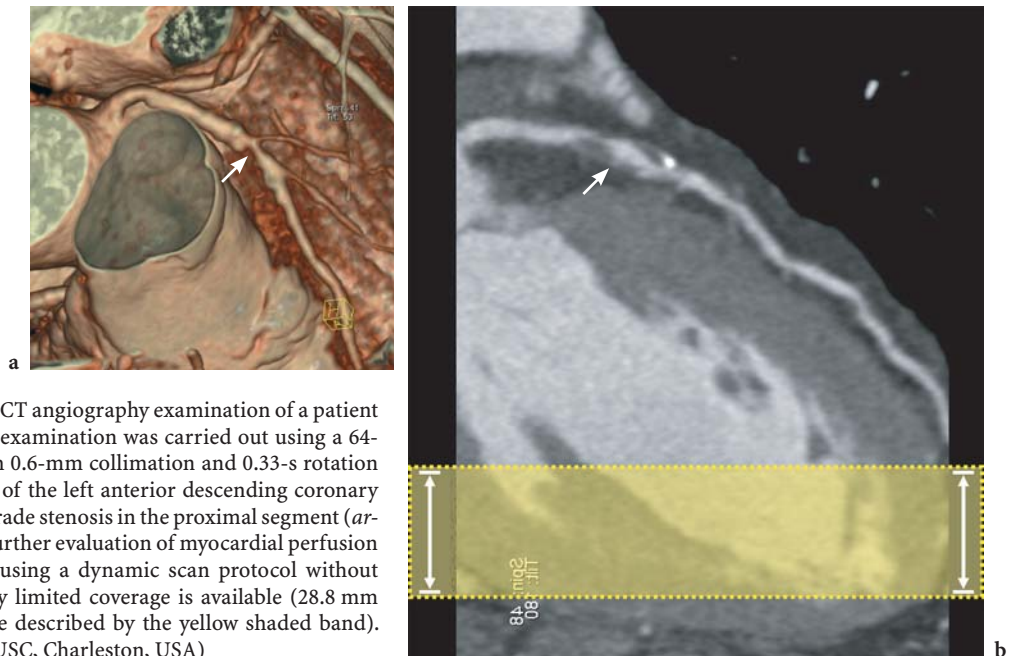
Coronary CT angiography examination of a patient with chest pain. The examination was carried out using a 64-slice CT scanner with 0.6-mm collimation and 0.33-s rotation time. a Visualization of the left anterior descending coronary artery reveals high-grade stenosis in the proximal segment (*arrow* in a and b). For further evaluation of myocardial perfusion in the affected area using a dynamic scan protocol without table movement, only limited coverage is available (28.8 mm in this scanner, range described by the yellow shaded band). (Case courtesy of MUSC, Charleston, USA)
